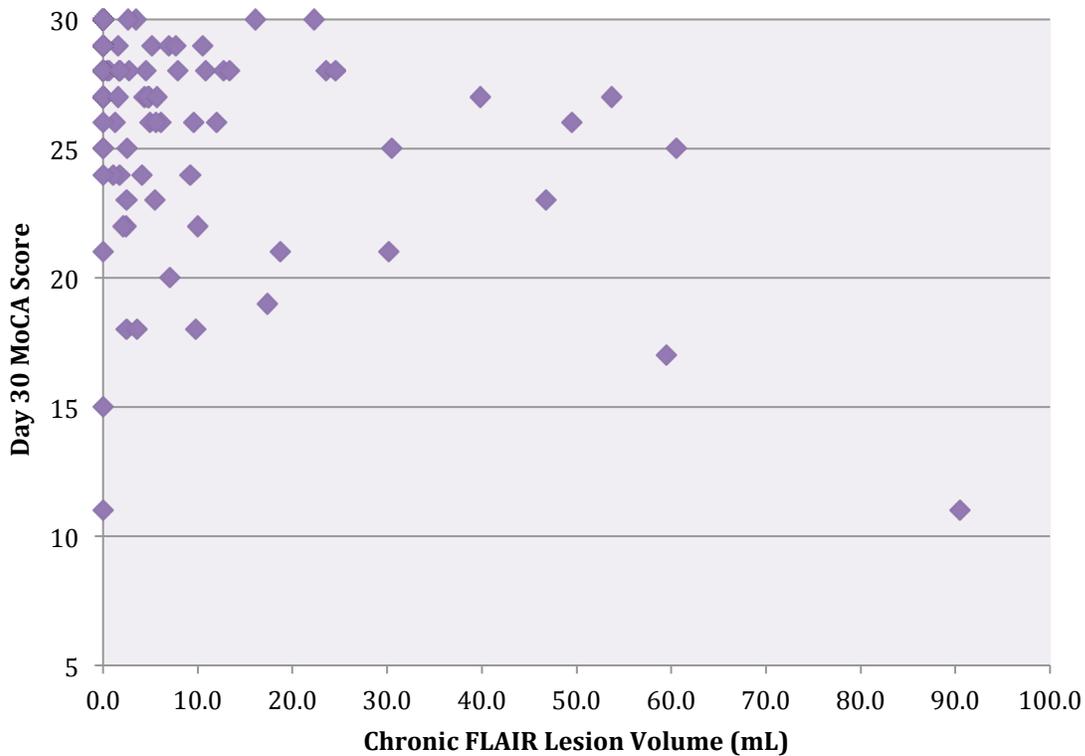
Chronic day 30 FLAIR lesion volume demonstrates no significant relationship to patient MoCA scores at day 30. FLAIR indicates fluid attenuated inversion recovery; MoCA, Montreal Cognitive Assessment.
